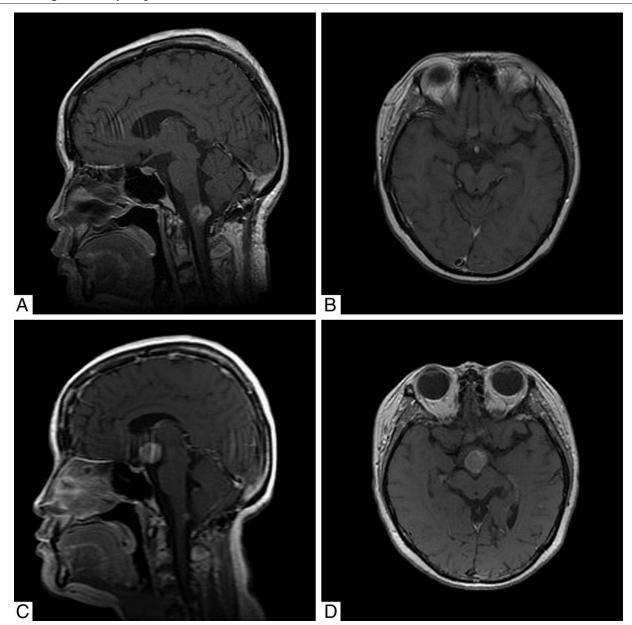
A, Sagittal T1 with contrast MRI demonstrates an enhancing mass at the medullary junction. B, Axial T1 with contrast MRI demonstrates no signs of a suprasellar mass. Sagittal (C) and axial T1 (D) with contrast MRI demonstrate an enhancing suprasellar mass.
